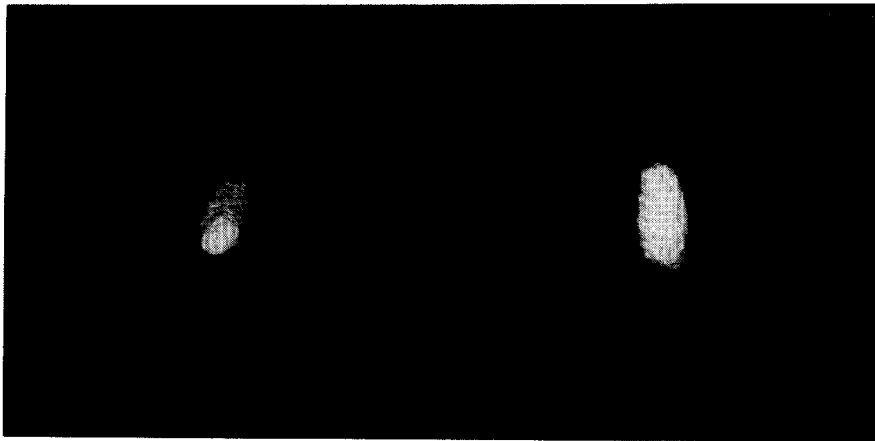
The three-dimensional CT images of the gallbladder of a volunteer 30 min after cerulein injection. The volume of the gallbladder was measured to be 2.4 ml. It was calculated that GBCR was 92%.
